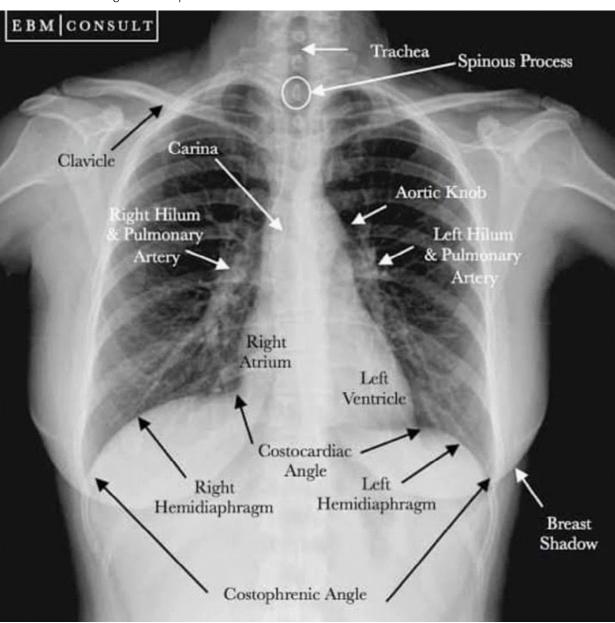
X-ray chest PA view
